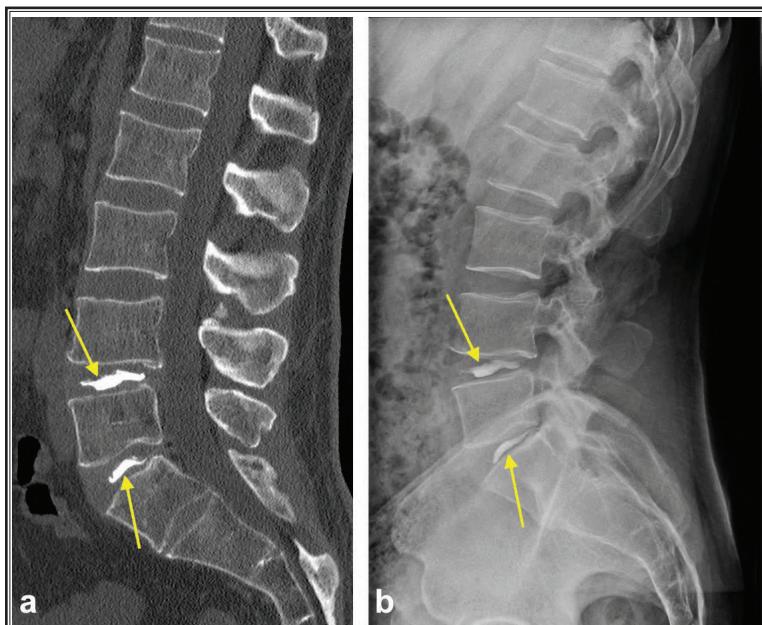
Lumbar spine of male patient, age 44 years at time of implantation, with injectable hydrogel (yellow arrow) implanted in the lumbar disc nucleus between L4 and L5 and between L5 and S1 vertebrae, with 1.0 mL injected per level: a) sagittal view CT image at one month after implantation; b) sagittal view radiograph at 6 months after implantation.
